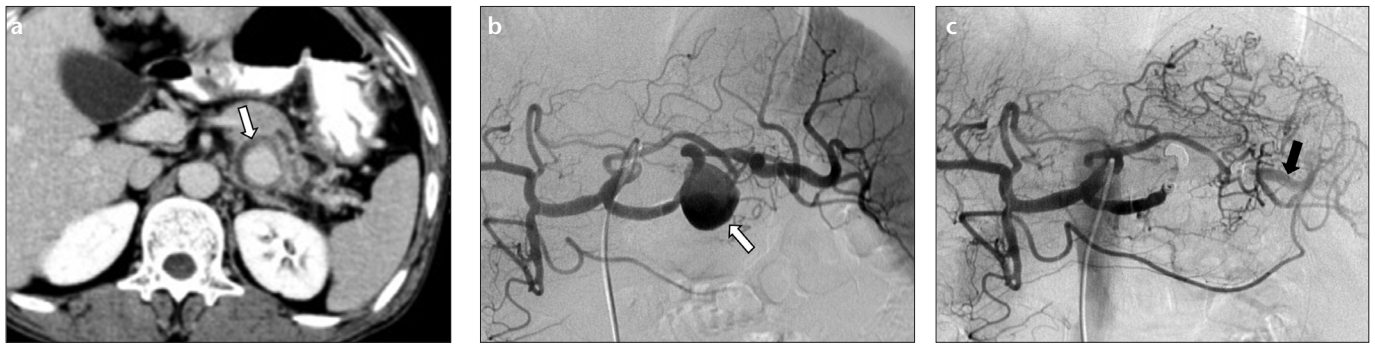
a–c. A 41-year-old male with chronic alcoholic pancreatitis was evaluated for left flank pain. Axial contrast-enhanced CT image (a) reveals a very large pseudoaneurysm (arrow) posterior to the body of the pancreas. Splenic arteriogram (b) demonstrates the pseudoaneurysm (arrow) arising from the middle segment of the splenic artery. The proximal and distal segments of the splenic artery were embolized using coils in order to exclude the pseudoaneurysm. Completion splenic arteriogram (c) confirms complete exclusion of the pseudoaneurysm sac. Meanwhile, the distal segment of the splenic artery (black arrow) is opacified via collaterals in the stomach and pancreas. The patient was discharged four days later, after an uneventful recovery period.
